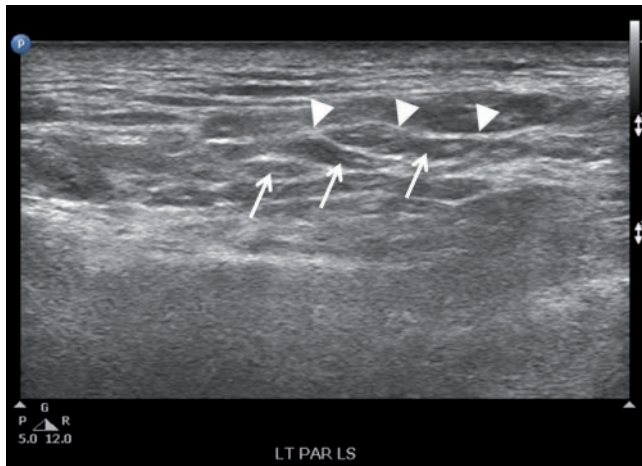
Sonogram shows a longitudinal scan of a parotid gland in a patient treated with conventional radiotherapy. There are multiple hypoechoic areas (arrows) within the gland, and the intraglandular ducts (arrowheads) are obviously seen.
